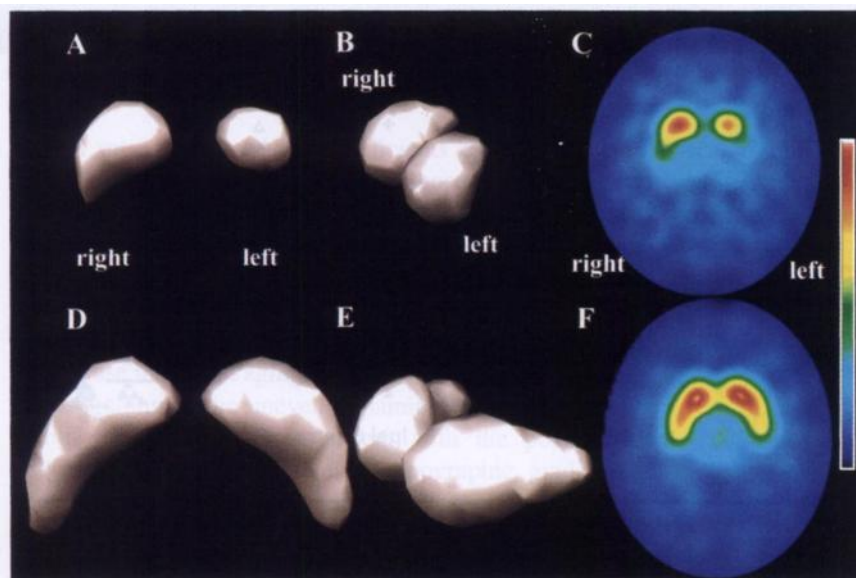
Three-dimensional surface displays (A, B, D and E) and ¹²³I-β-CIT SPECT images (C and F) of 53-y-old patient with Parkinson's disease (top row) and age-matched healthy individual (bottom row). Surface displays demonstrate truncation of putamen, degree being more marked on left than right for patient (A and B) compared with healthy subject (D and E). Patient (patient 3) had clinically unilateral parkinsonism. Patient's topographical abnormalities of striatum are also apparent on SPECT image (C).
